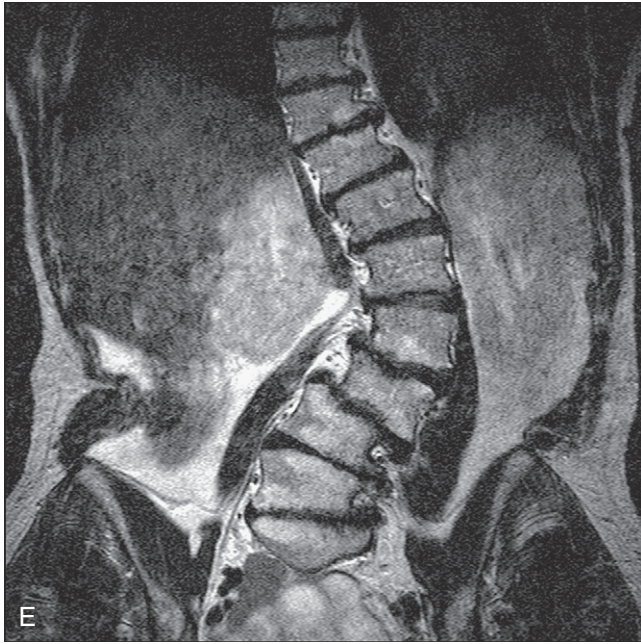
A, T1-weighted sagittal image through the lumbar spine. Fat is hyperintense on T1 images and is seen in the subcutaneous soft tissues (*arrowheads*), interspinous regions (*short arrows*), epidural space (*long arrows*), and bone marrow (*asterisks*). The intervertebral discs are mildly hypointense relative to the vertebral marrow. The CSF is hypointense relative to all but cortical bone. B, T2-weighted sagittal image. In this sequence, the CSF is the most hyperintense (*white*) structure. Fat remains hyperintense (*arrowheads*) but is less bright than on the T1-weighted sequence. Note the high signal intensity within the intervertebral discs indicating normal disc hydration (*short arrows*). A small, normal hypointense intranuclear cleft is visible in many discs including at L1–L2. C, The STIR sequence is a T2-weighted sequence with a fat-suppression technique. The CSF remains hyperintense but the fat has “dropped out” and is now hypointense. Edema is easily depicted in the vertebral bodies or soft tissues using this sequence. D, The GRE sequence is a fast T2-weighted sequence that is particularly susceptible to inhomogeneities in the magnetic field as are produced by blood, calcium, and metal. In this image the discs (*short arrow*), CSF (*asterisk*), and basivertebral plexi (*dashed oval*) are hyperintense whereas the bone and fascial planes are hypointense. Blooming (*long arrows*) is seen dorsal to C7–T5 due to metallic surgical hardware.
